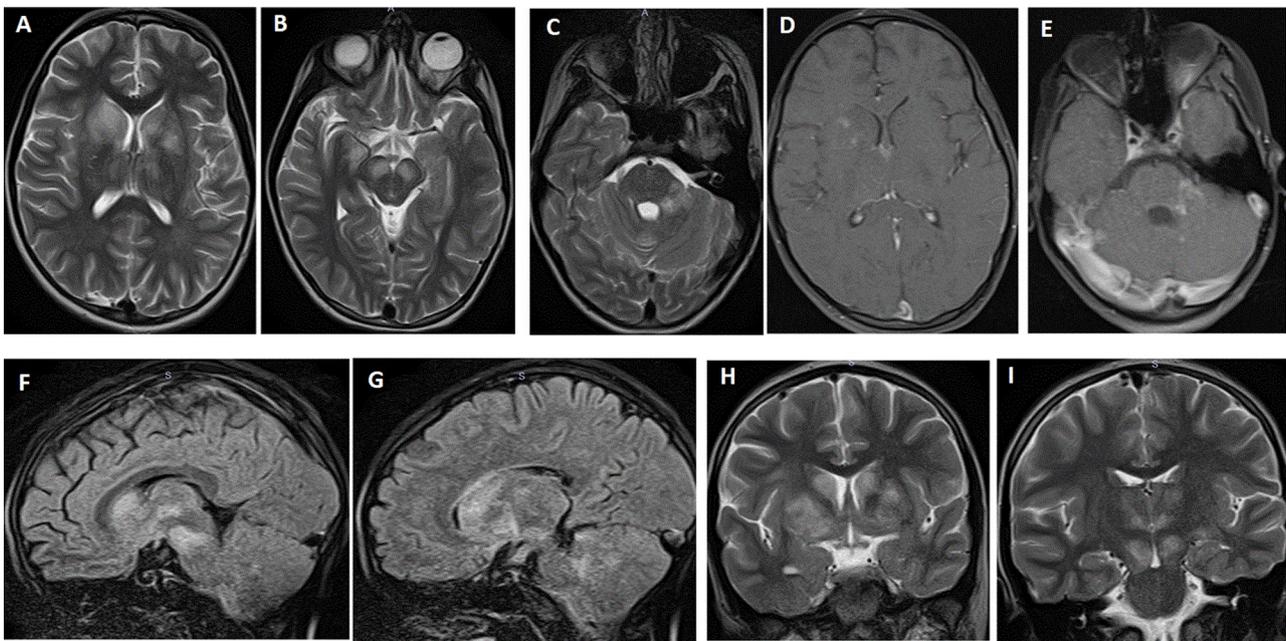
Brain MRI (2,5 Months after the seizure episode).
